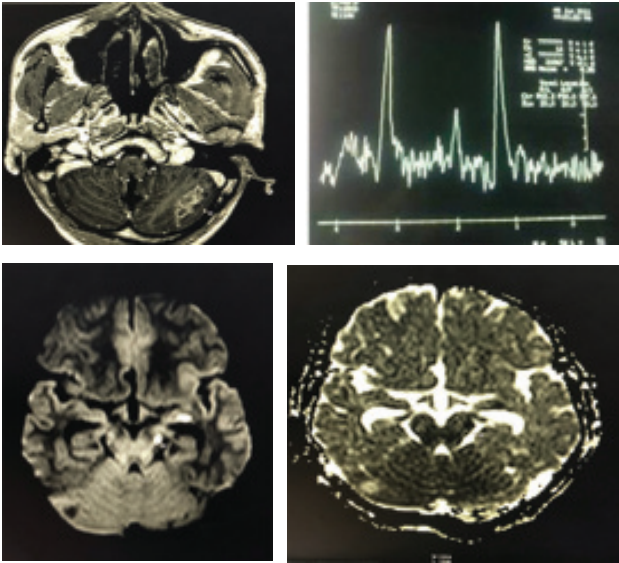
A 25-year-old male patient with TBM, tuberculomas and infarct: Post-contrast T1 axial image shows nodular enhancing lesions in inferior aspect of left CP angle with leptomeningeal enhancement in cerebellar folia. MRS shows lipid peak at 1.3 ppm. DWI/ADC mapping show restricted diffusion in left cerebral peduncle of midbrain and medial temporal lobe.
